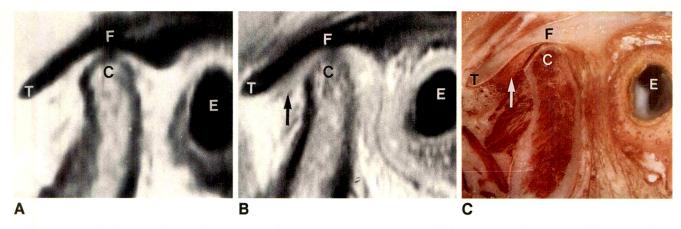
A and B, MR images obtained at 0.3 (A) and 1.5 T (B) show anterior displacement of disk. Anterior is to left. Image quality with respect to delineation of disk was rated superior on 1.5-T image (B). Position of disk could not be seen clearly in 0.3-T image (A).
